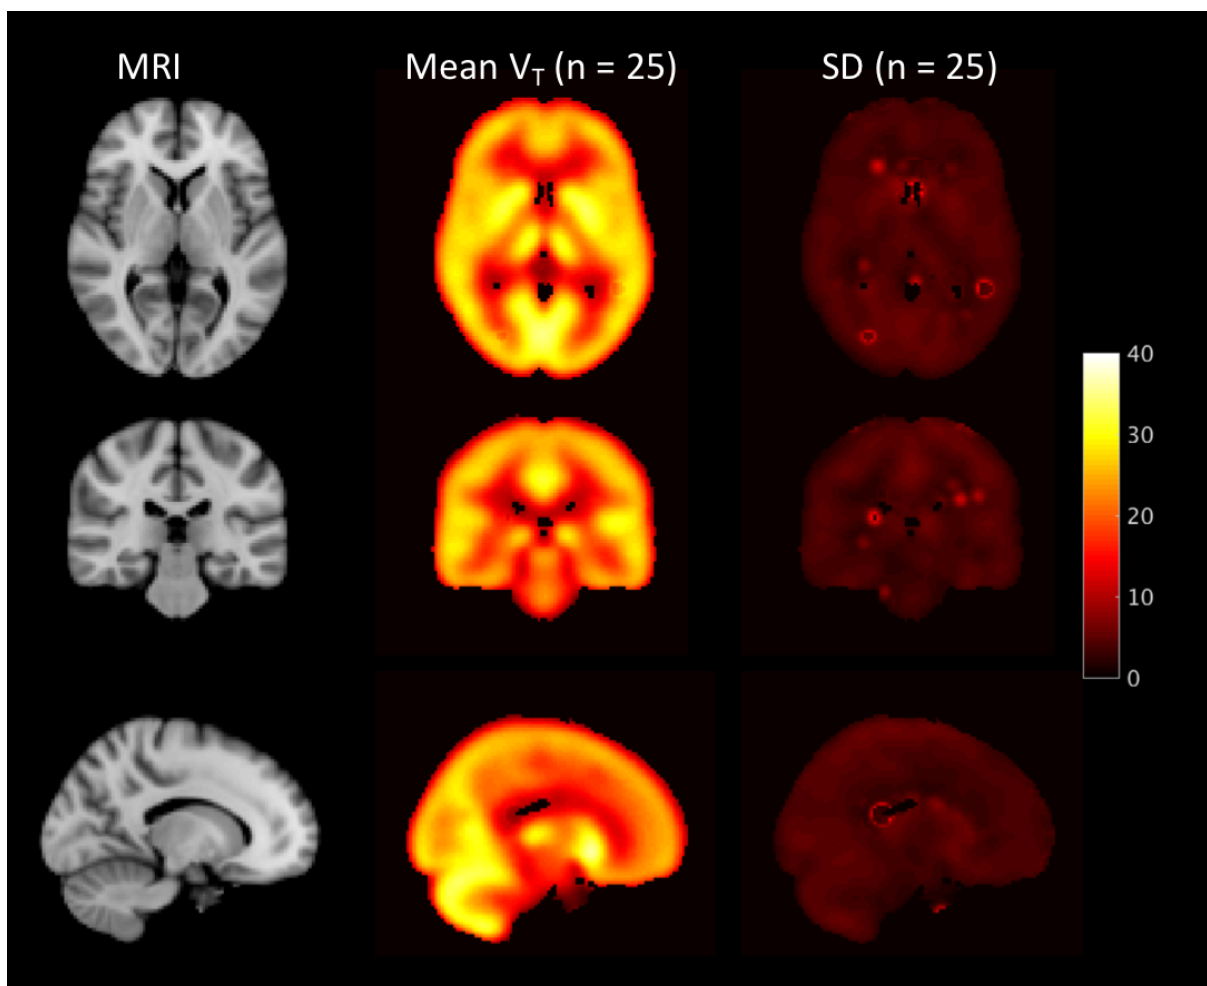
Orthogonal cross-sections of MRI (left), mean (middle) and standard deviation (SD) (right) V_T images of ^{18}F -BCPP-EF (n=30).
